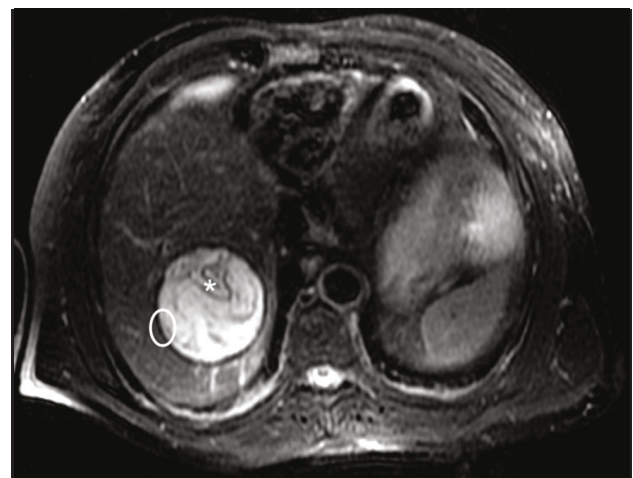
Axial fat-suppressed (FS) T2-weighted MRI of the abdomen shows a focal lesion in segment VII of the liver with heterogeneous, mainly high, signal intensity, with linear structures of low signal intensity with an appearance of "detached membranes" (asterisk), associated with ring of low intensity signal corresponding to the signet ring sign (white ellipse). Gharbi type II-CE3.
